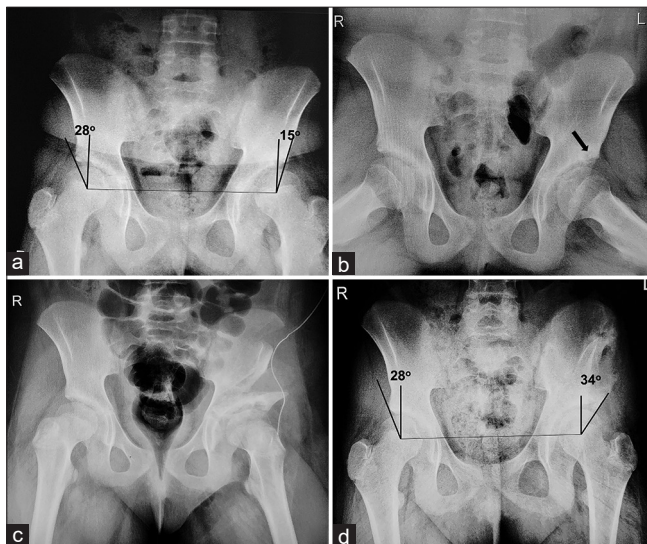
An 11-year-old girl who presented with left hip and thigh pain. (a) AP pelvic radiograph shows acetabular dysplasia of the left hip with superior subluxation of the femoral head and a central-edge angle of 15°. (b) AP radiograph in abduction shows a cyst (arrow) at the lateral part of the acetabulum and disrupted Shenton's lines (dotted curves) bilaterally. (c) Immediate post-operative radiograph after pemberton acetabuloplasty without cast and internal fixation shows good coverage. (d) AP radiograph 11 years after surgery shows a good acetabular cover with a central-edge angle of 34°.
